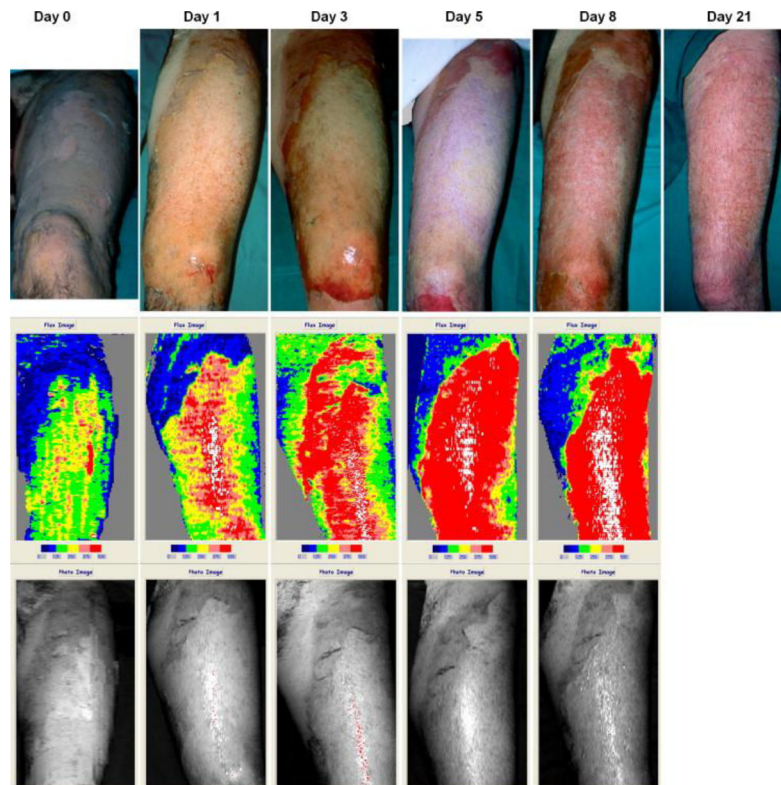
Laser Doppler imaging at day 0, 1, 3, 5 and 8 post-burn, showing wound healing and increasing perfusion. The healed wound at day 21 post burn is also shown, adopted with permission from [5].
